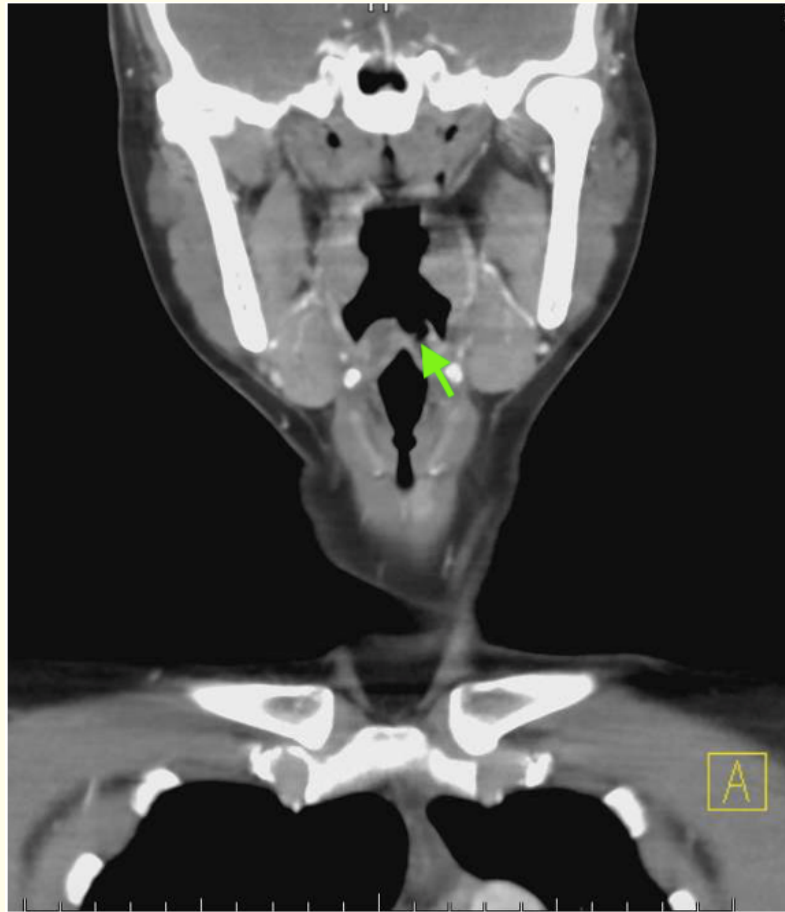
CT neck coronal view shows gas within the epiglottis (green arrow).
